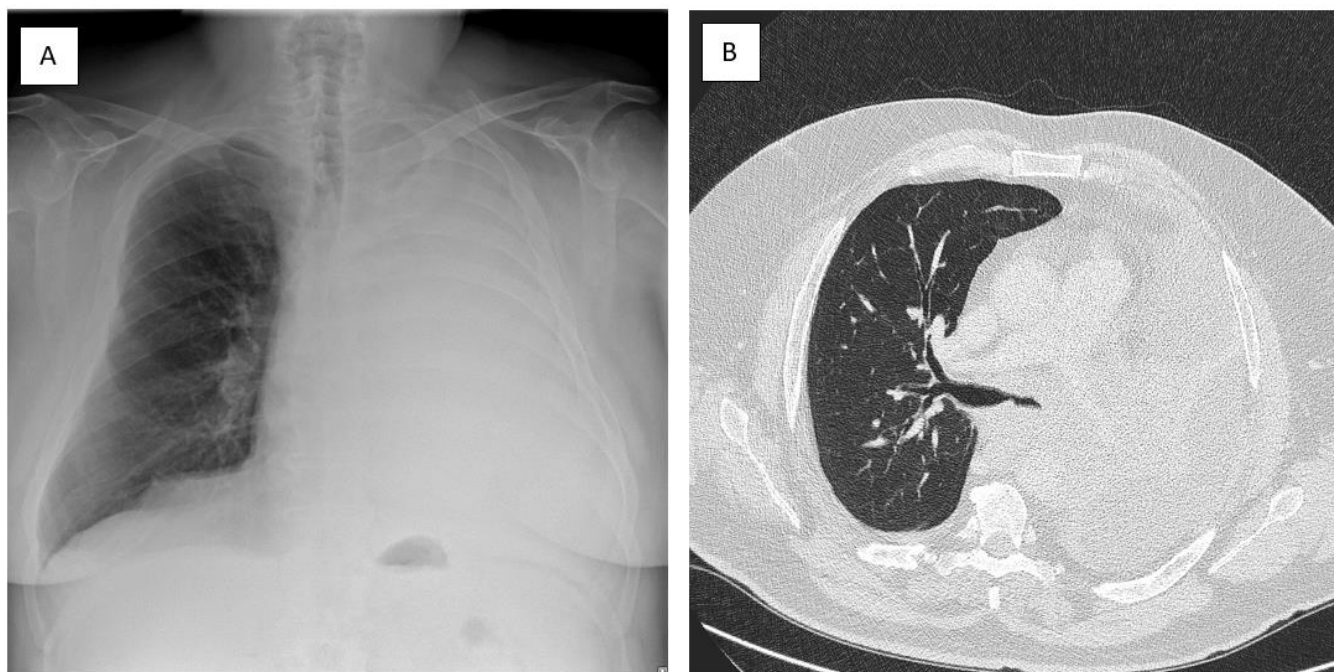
A) Pre-treatment chest radiography showing extensive opacification of the left hemithorax with contralateral (right) mediastinal shift and reduced left lung volume; B) Pre-treatment chest computed tomography demonstrating a large left perihilar mediastinal mass (11 × 7 × 13 cm) causing narrowing of the left main bronchus, occlusion of the left lower lobar bronchus and compression of the pulmonary artery, associated with loculated pleural effusion and multiple supra- and infradiaphragmatic lymphadenopathies.
